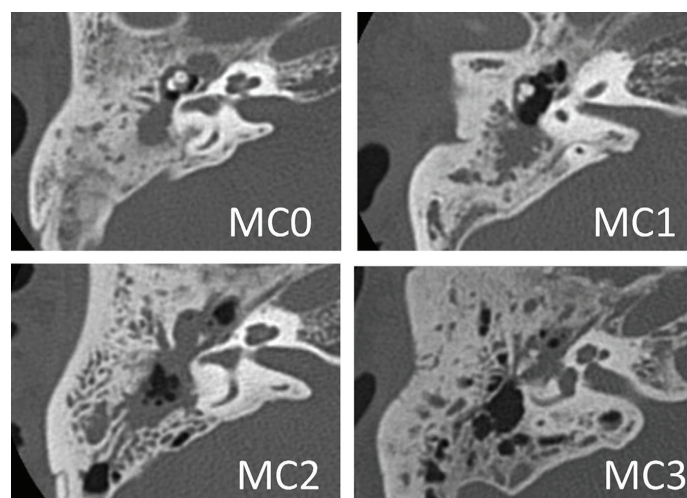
Axial CT images representing degrees of mastoid cell development (MC0-MC3) (Adapted from Tono et al. [2] 2017).
